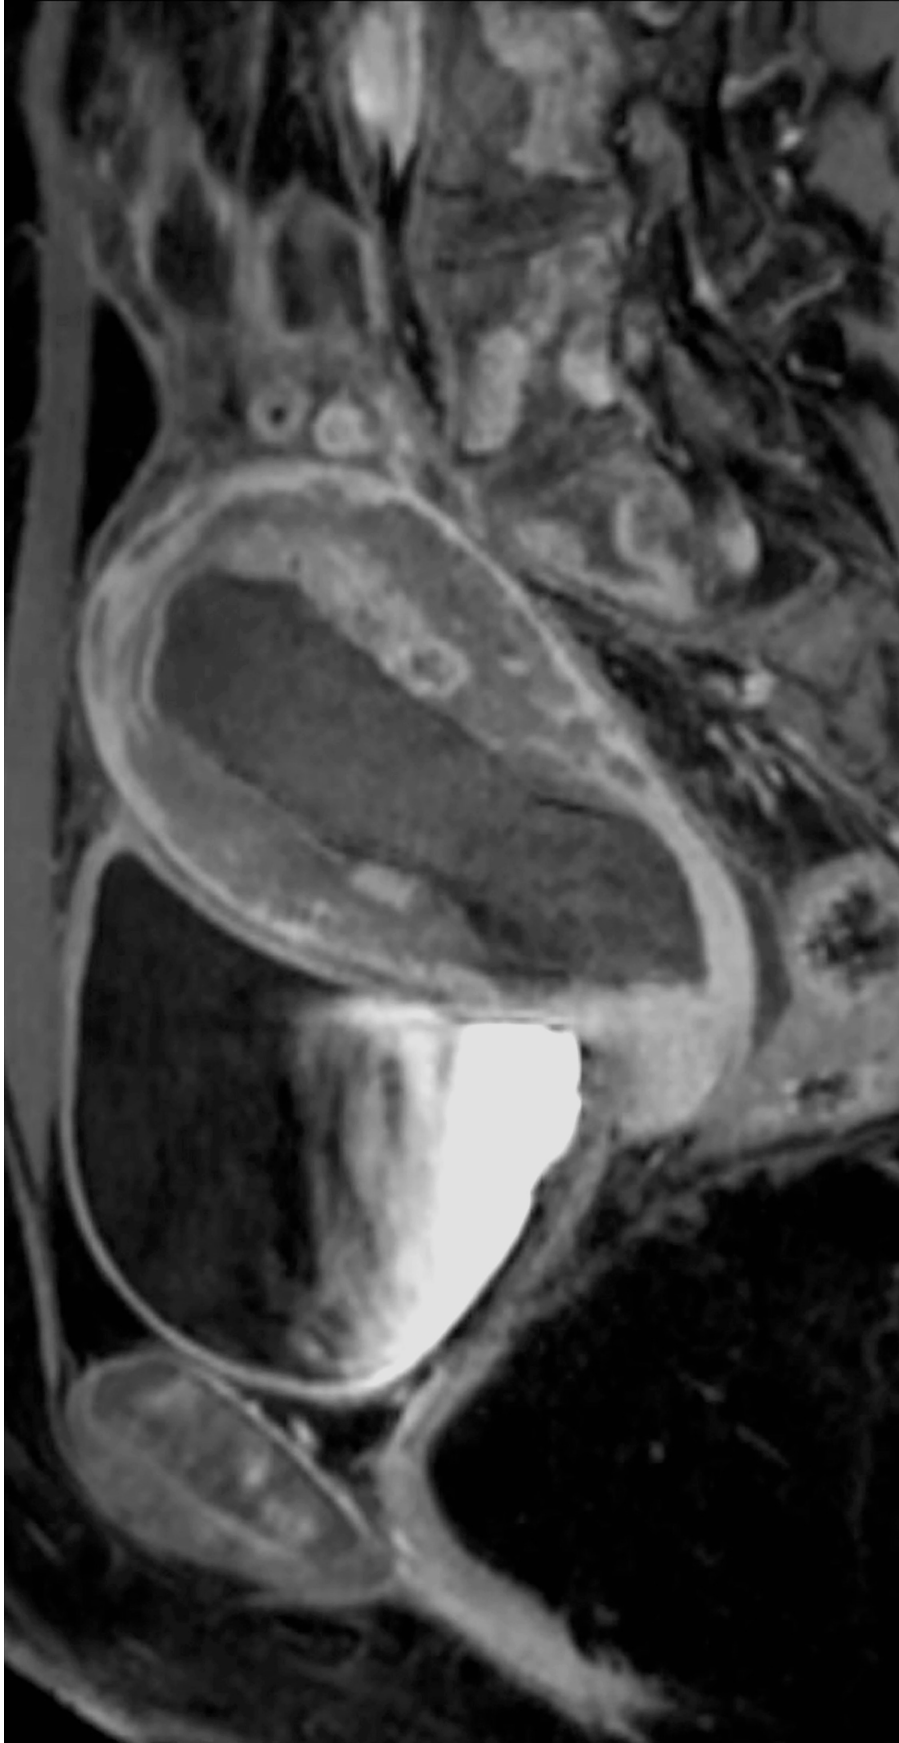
Abdomino-pelvic MRI. Sagittal T1 contrast-enhanced section which showed heterogeneous thickening of the entire uterine wall, identifying a widened myometrium occupied by a hypointense infiltrative lesion suggestive of leukaemic infiltration.
